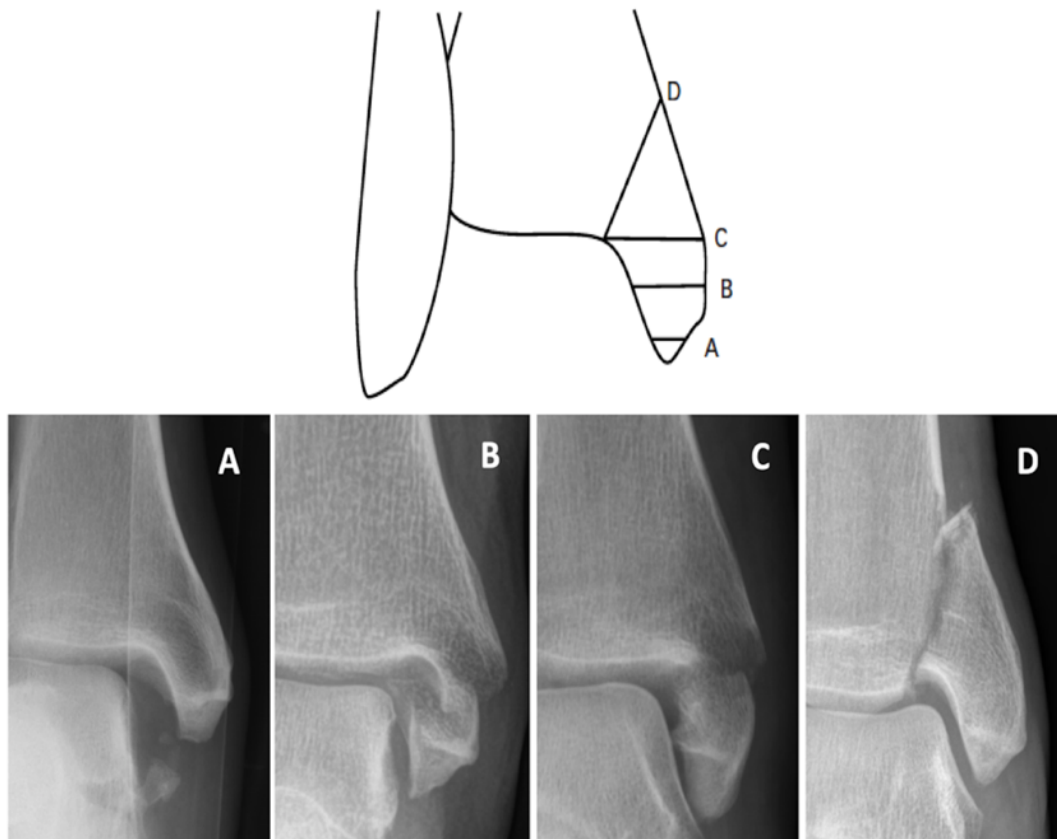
Herscovici classification of medial malleolar fractures with radiographic examples<sup>60</sup>.
